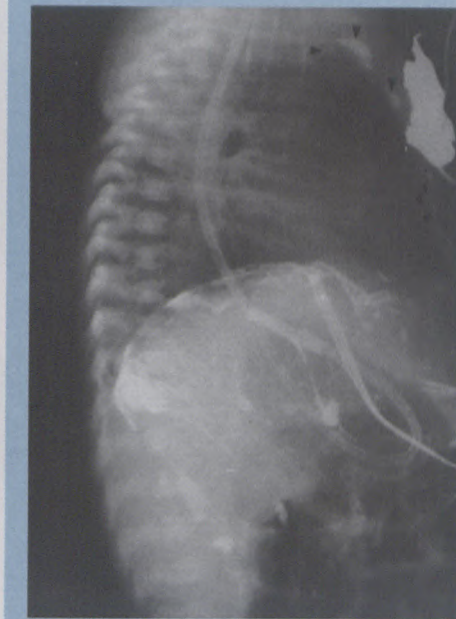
Post-operative lateral chest radiograph confirms the retrosternal position of the barium (arrowheads) in keeping with its drainage via the internal thoracic lymphatic chain.
